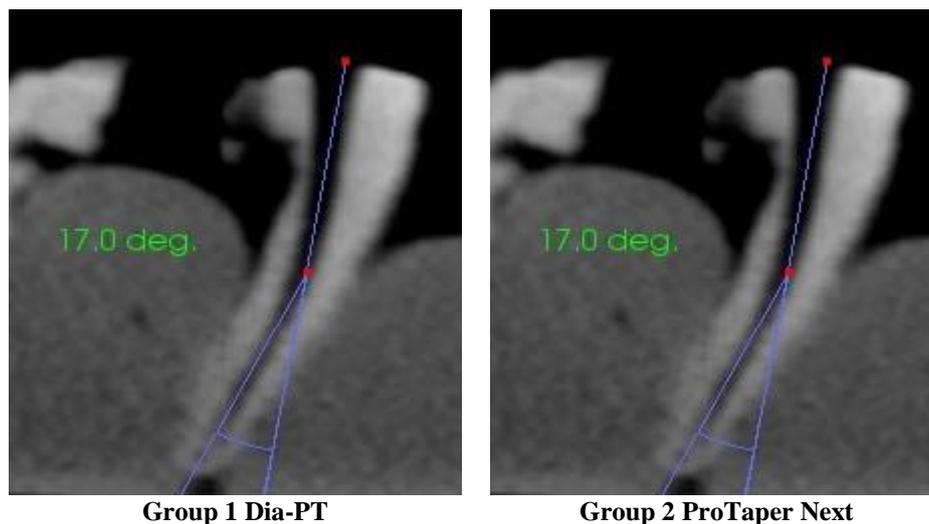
CBCT sagittal view showing degree of canal curvature.
